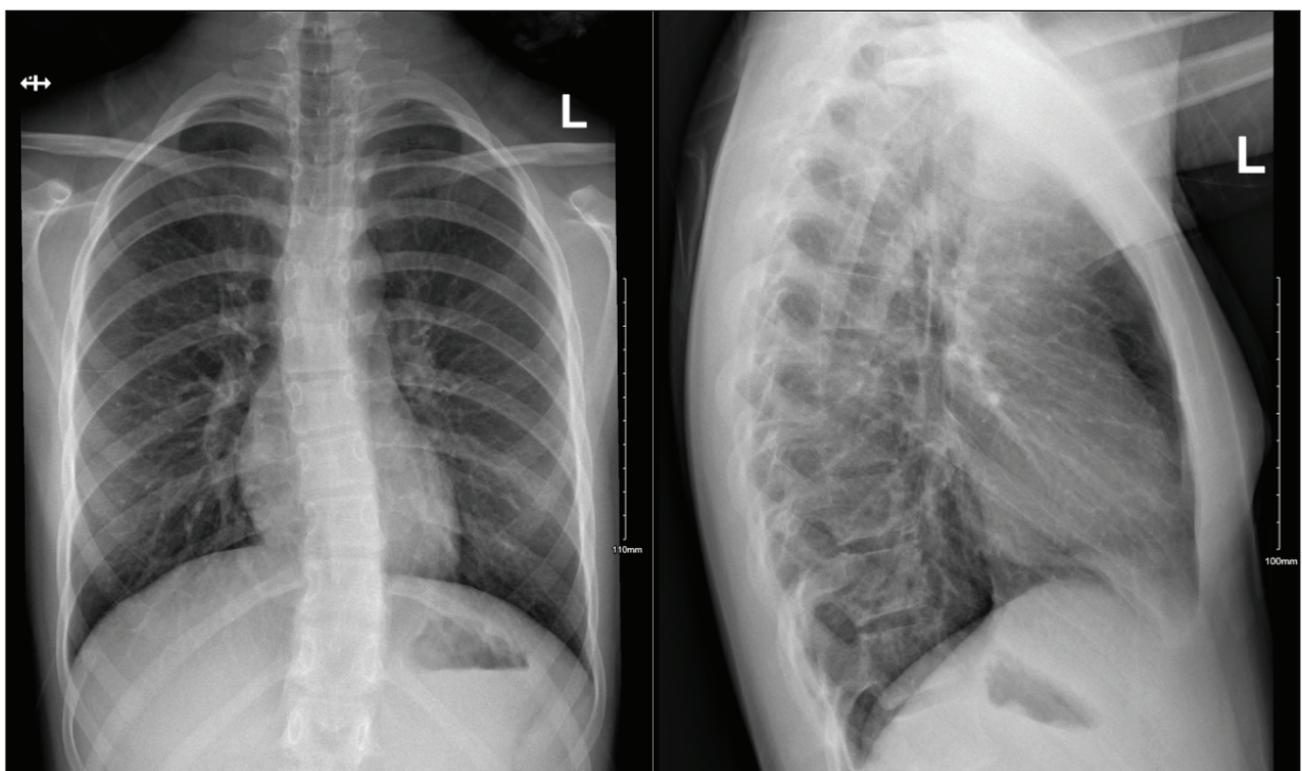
Chest radiographs from the second visit showing a PA view and a lateral view.
